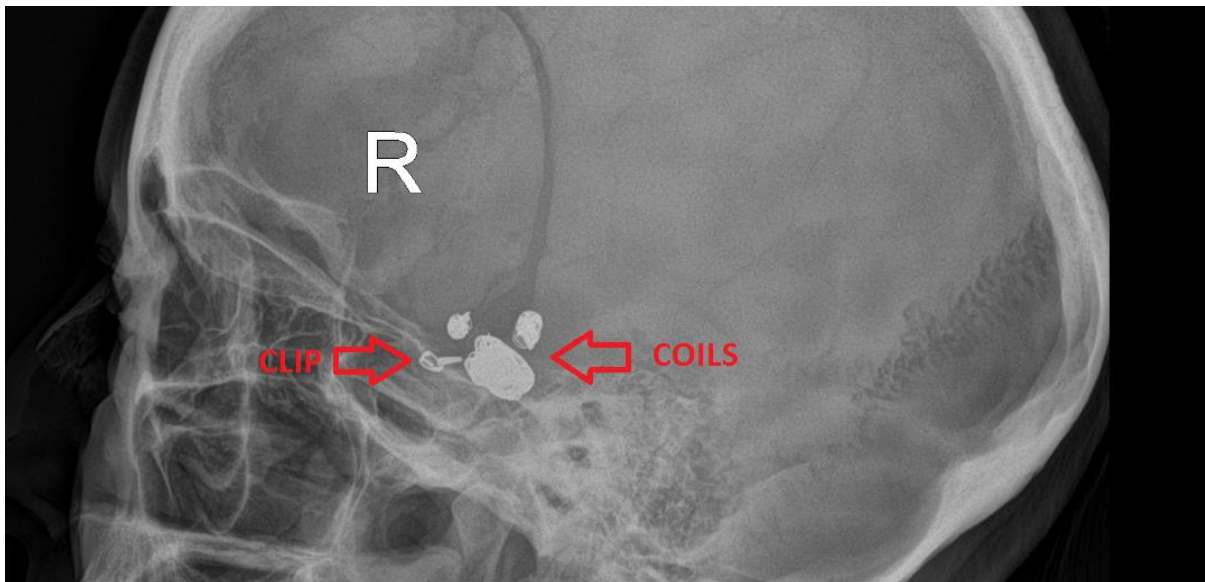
X-ray of patient with an aneurysm clip and 3 embolisation coils
